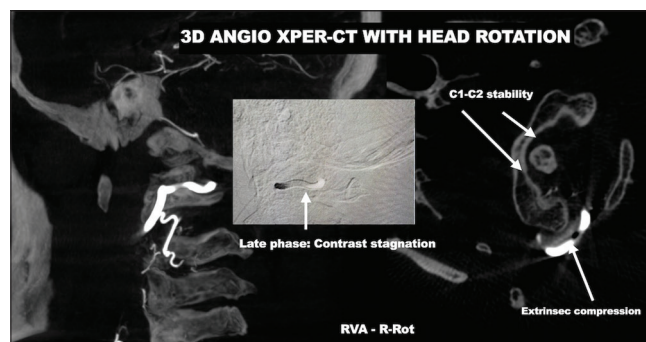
3D XPER-computed tomography angiogram, right head rotation. The lateral view confirms contrast stagnation in the late phases at the C1 vertebral groove. Axial view confirms the atlantoaxial joint is stable. RVA: Right vertebral artery, R-Rot: Right head rotation.
